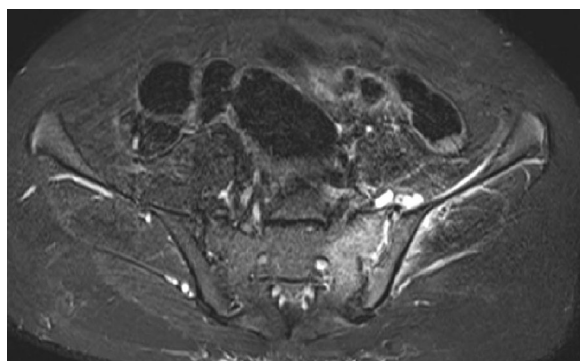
Magnetic resonance imaging axial scan shows left-sided inflammation of the soft tissues around the sacroiliac joint and presence of fluid collections or abscesses around the joint
